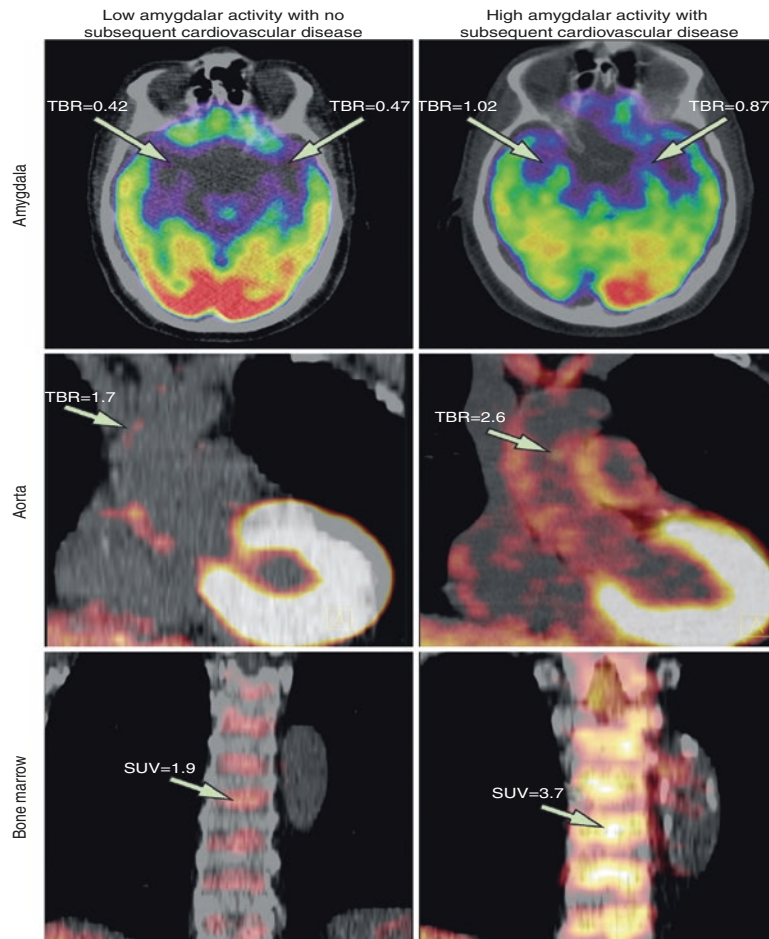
Multimodal FDG PET-CT imaging was performed in 293 individuals who were subsequently followed for incident cardiovascular disease (CVD) events. FDG uptake was assessed in the amygdala (a neural structure that is critically involved in the stress response), the arterial wall (an index of atherosclerotic inflammation), and in the bone marrow (an index of leukopoiesis). Shown are axial views of the amygdala (top), coronal views of the aorta (middle), and coronal views
